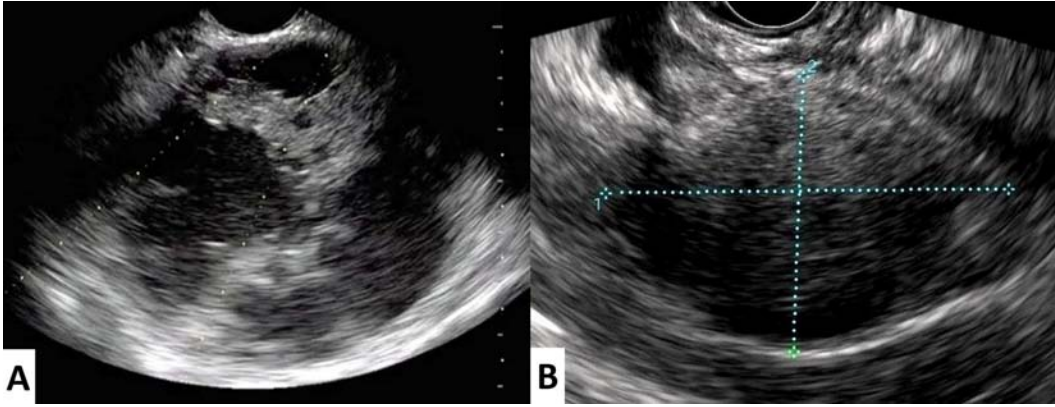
Endosonographic images showing a suspected SPN: A) Solid-cystic morphology. B) A solid lesion with well-defined borders.
